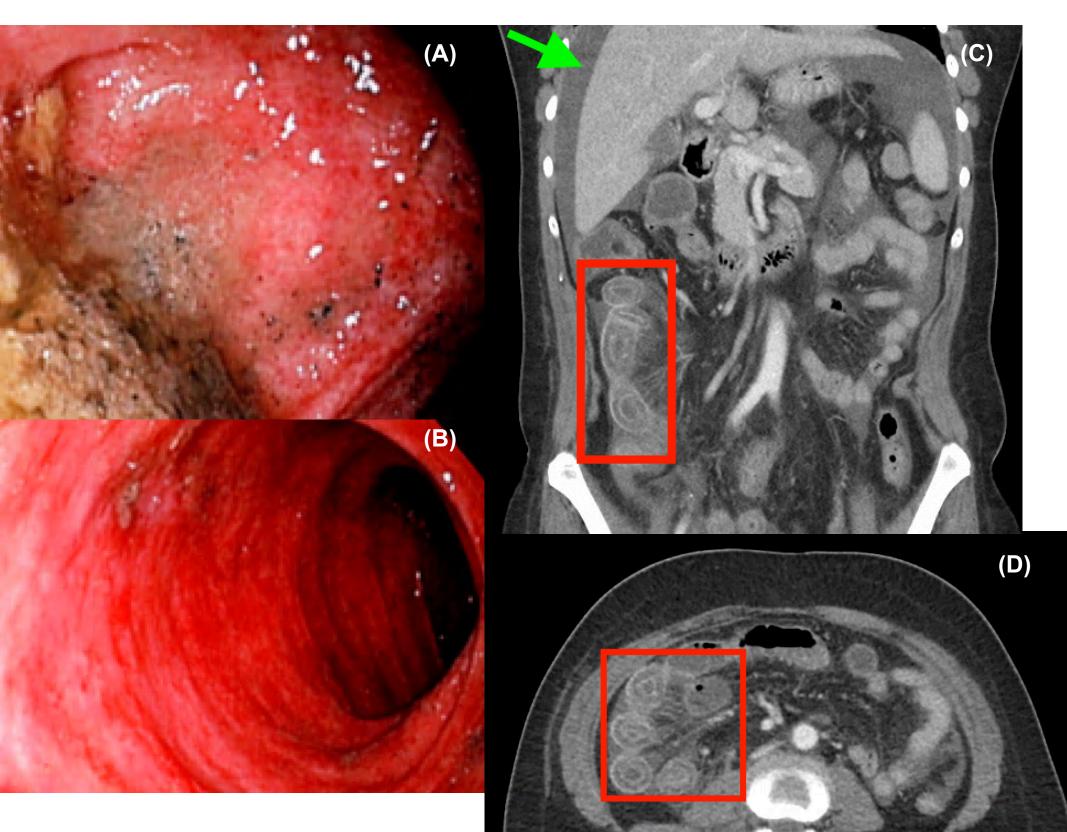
(A & B) Endoscopically visualized moderately hyperemic right colon with patchy loss of vasculature (C) Green arrow indicating ascites and red box highlighting characteristic bowel wall edema (target sign) on CT Abdomen/Pelvis with IV Contrast. (D) Re-demonstrating the "target sign" on transverse view of CT Abdomen/Pelvis with IV Contrast. Presence of a"Target Sign" satisfies the radiologic evidence criteria for diagnosis of lupus enteritis.^{2,5}
